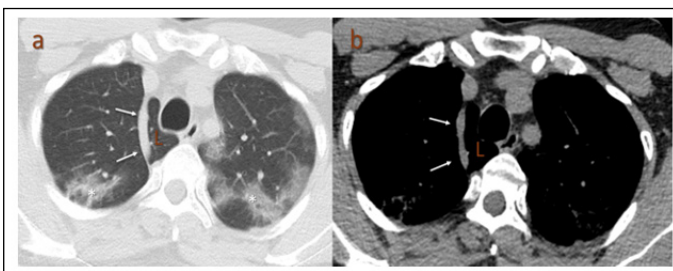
In a 48-year-old male patient who presented with shortness of breath, the azygos vein at the arrow and azygos lobe (L) are observed in the parenchyma (a) and mediastinum (b) window images of the non-contrast thoracic CT. Also, in the parenchymal window images, patchy ground-glass densities of both lungs are observed (*).
